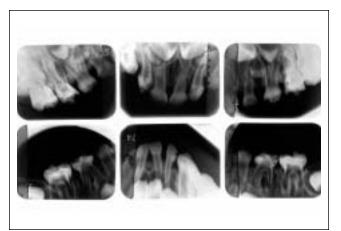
Dental radiographic findings showed expansion of the pulp cavity in all deciduous teeth.
